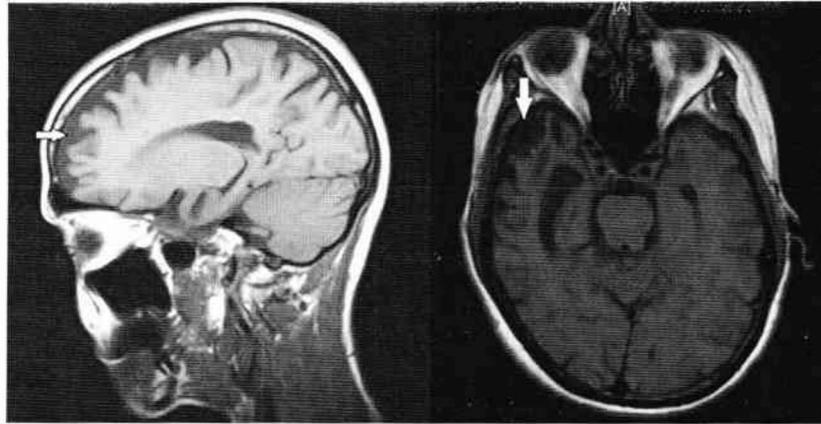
Frontotemporal lobar degeneration. Left: Brain magnetic resonance image of a 58-year-old woman with 1.5 years of personality change, loss of social graces, and behavioral disinhibition. Note the global atrophy, with frontal lobe predominance (white arrow), characteristic of behavioral-variant frontotemporal dementia Right: Evidence of focal anterior temporal lobe atrophy (downward white arrow), characteristic of a subtype of primary progressive aphasia caused by frontotemporal lobar degeneration. Courtesy: Seth Gale, MD (author), personal archive.
